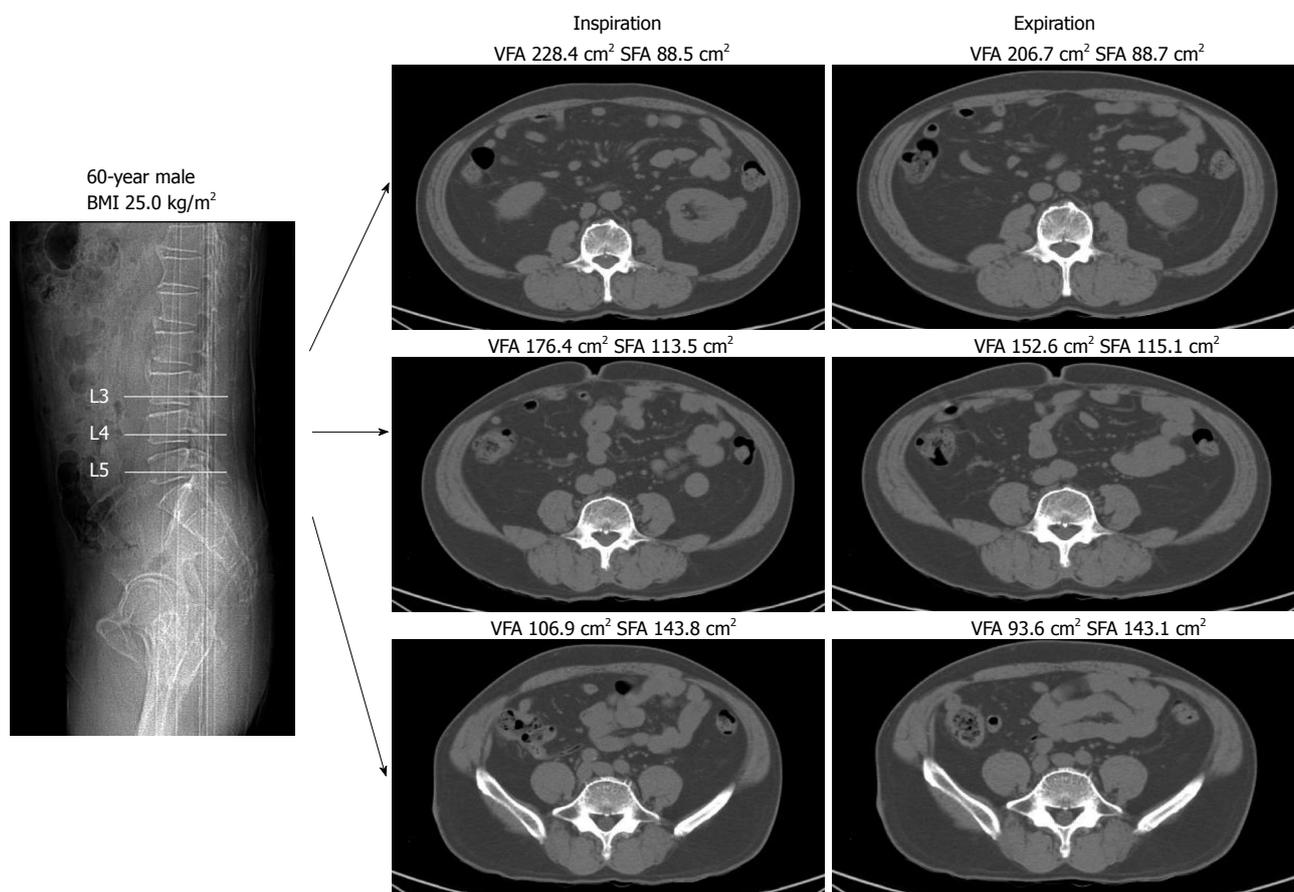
Measurement of visceral fat area varies with respiratory phase and level of computed tomography scan. Fat area measurement application: Advanced area calculation, GE Healthcare Co. VFA: Visceral fat area; SFA: Subcutaneous fat area; BMI: Body mass index.
